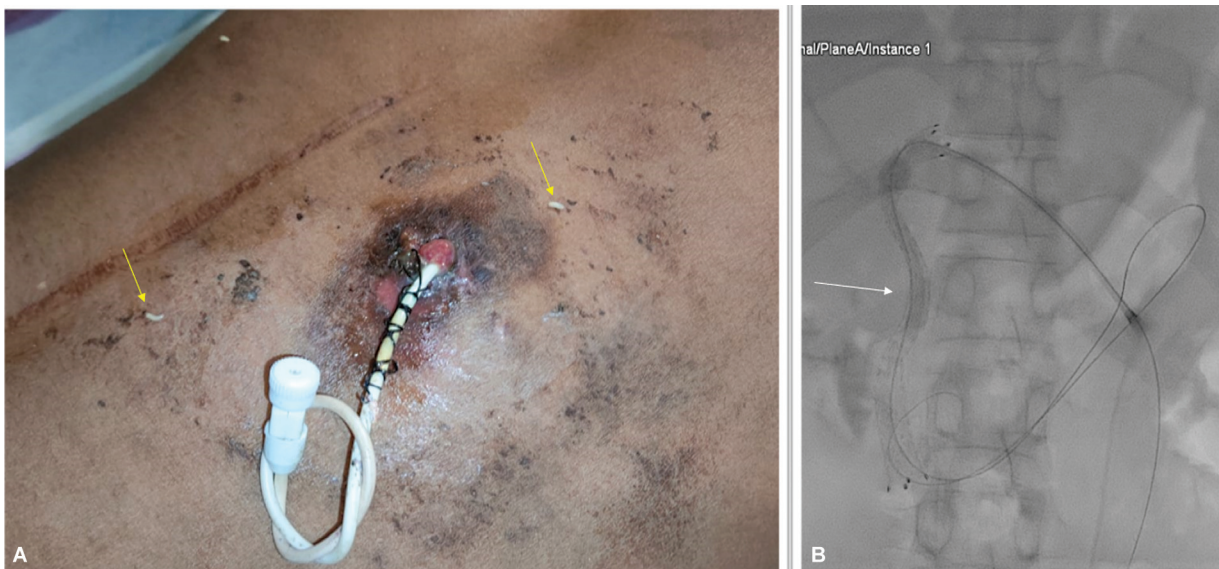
(A) Skin puncture site with percutaneous biliary drainage tube (internal–external drainage tube (8.5 Fr, Cook Medical, Bloomington) after removal of the bile-soaked dressing shows multiple larvae crawling around the wound (arrows). (B) Spot radiograph showing placement of a metallic biliary stent with a check catheter in situ after treatment of myiasis.
